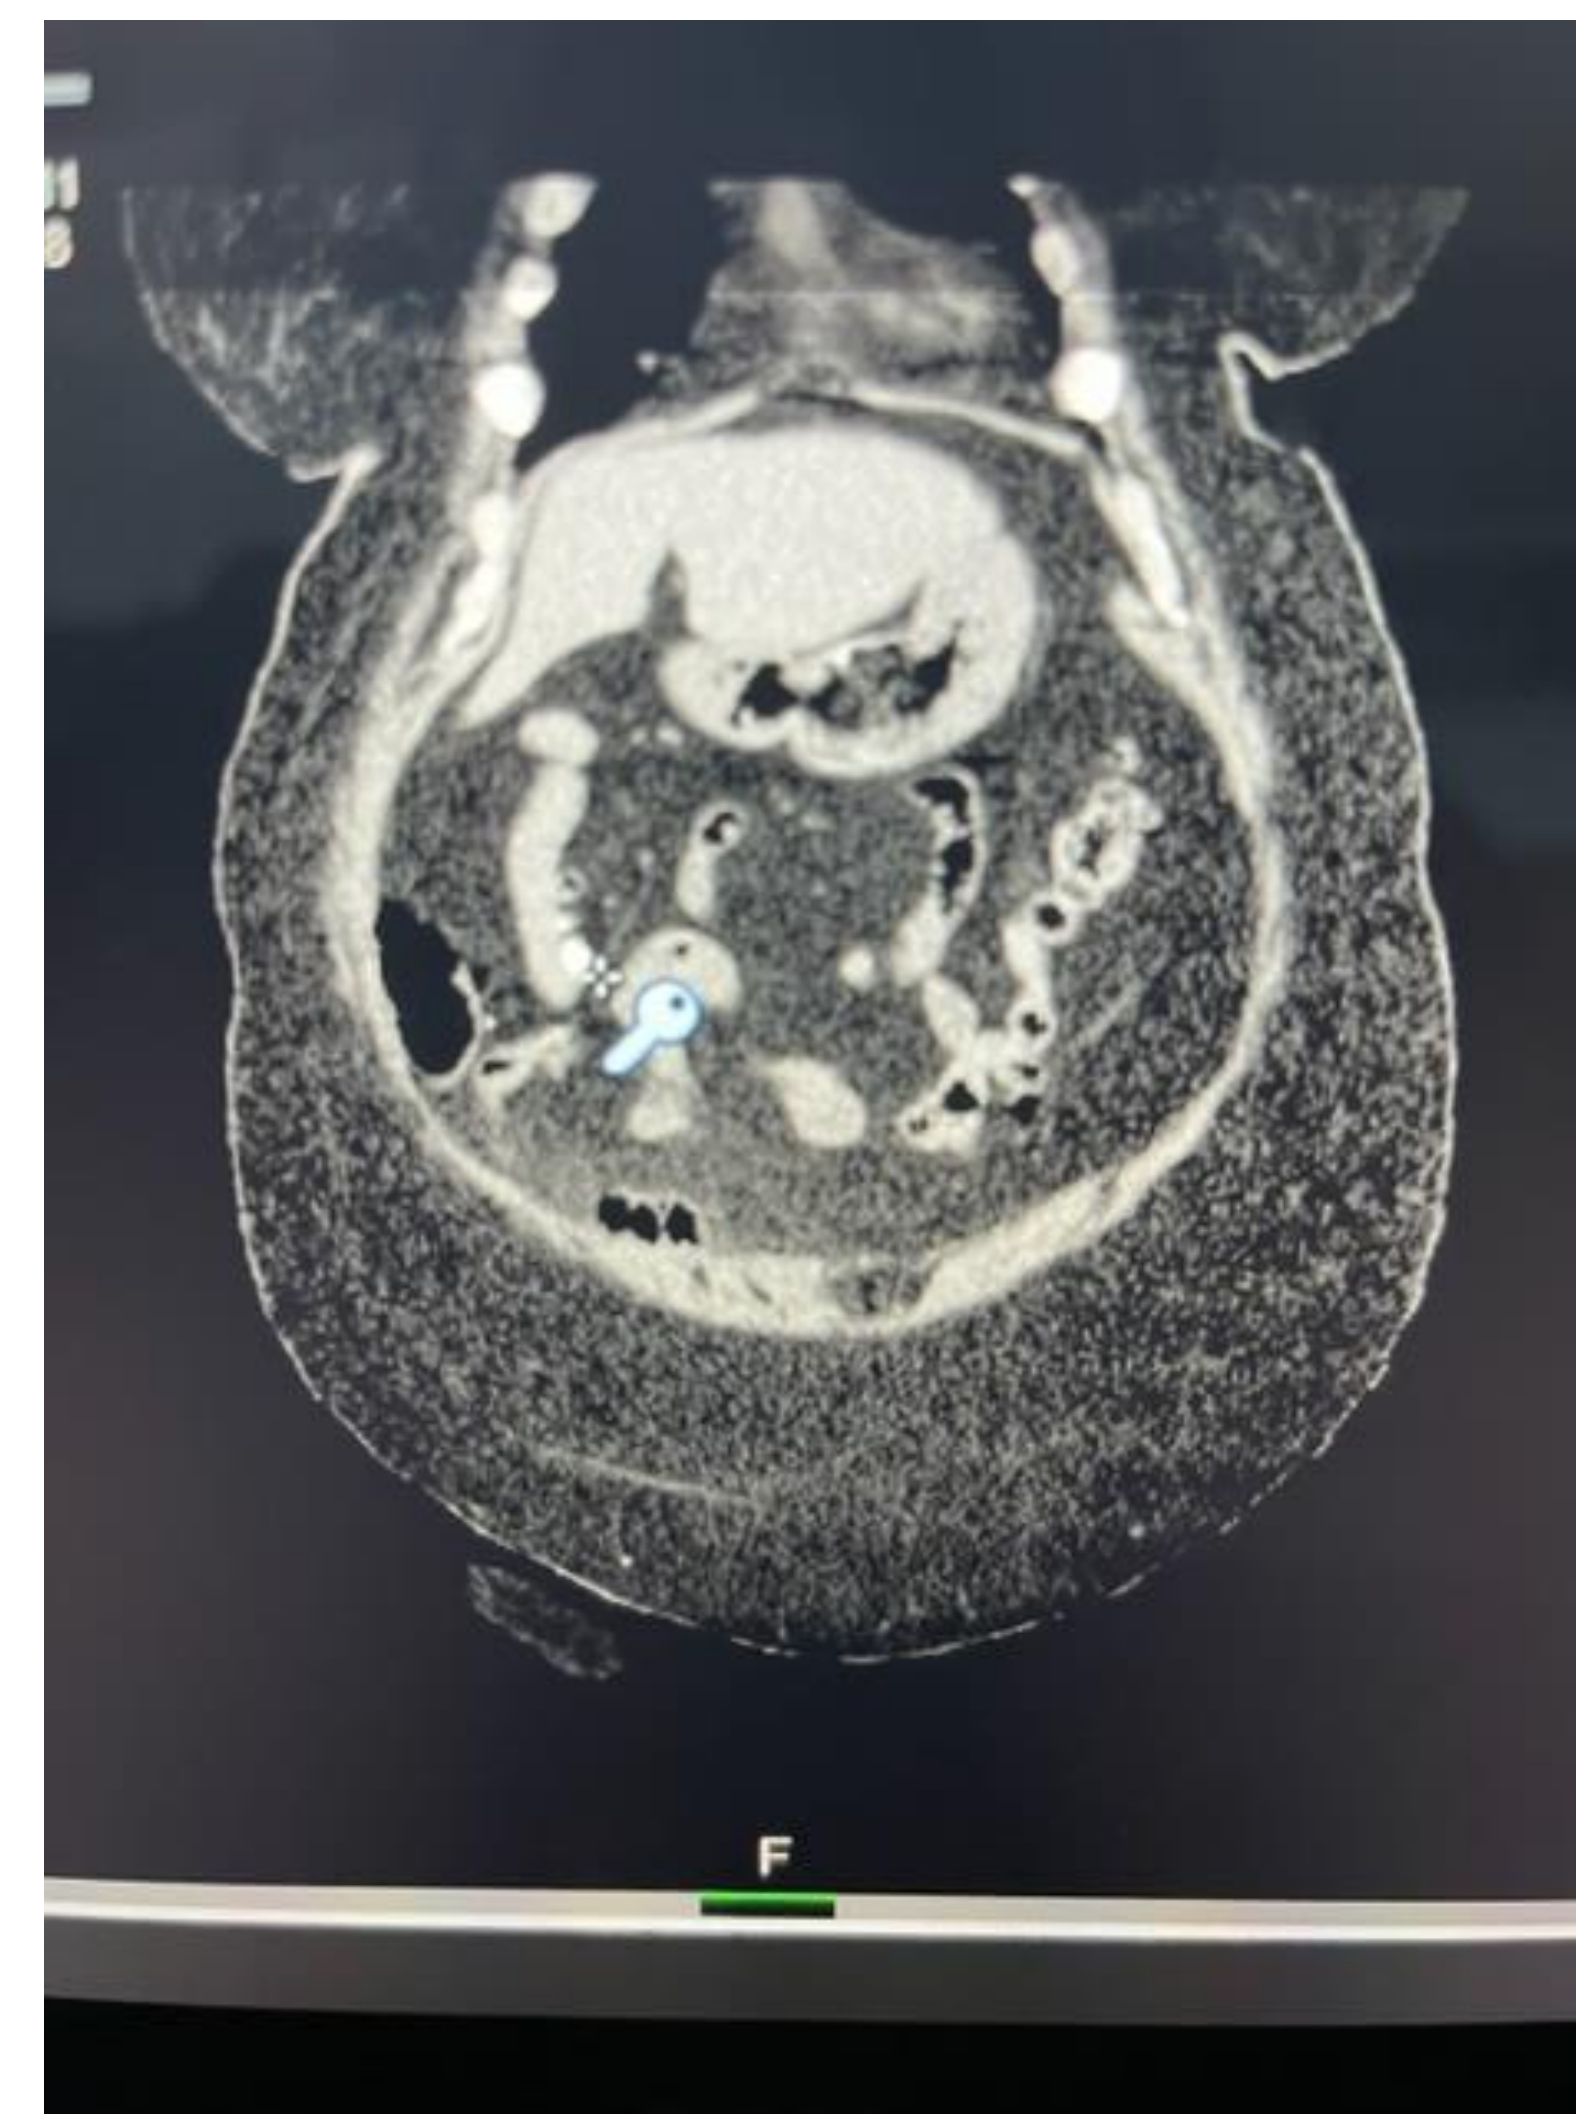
CT scan, coronal view. Index marker identifies the Meckel's Diverticulum with calcification
